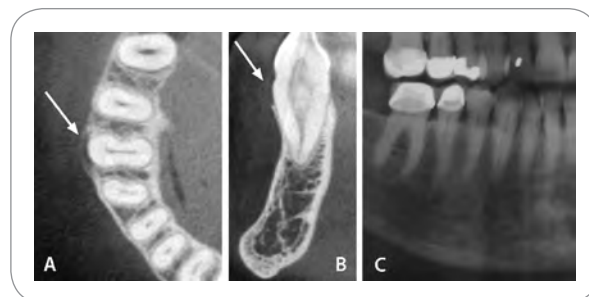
Gingival squamous cell carcinoma in the region of tooth No. 27. A and B were acquired using Accuitomo 3-D CBCT machine. Images were reformatted in One Data Viewer. (A) Axial sections through cervical region of tooth No. 27 shows expansion and thinning of the buccal cortical plate (arrow). (B) Coronal section through tooth No. 27 shows expansion and thinning of the buccal cortical plate (arrow). (C) Sectional panoramic radiograph shows only a small horizontal bony defect near the cervical region of No. 27.
